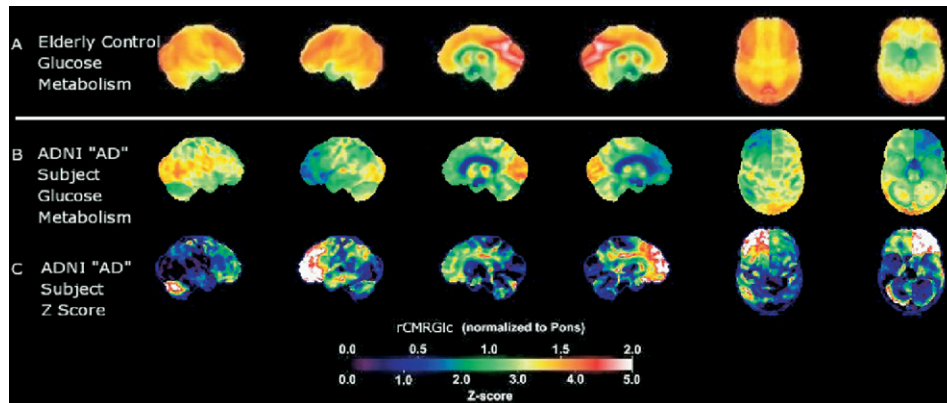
FDG-PET scan in a subject diagnosed with AD who shows an FTD pattern of glucose hypometabolism. Results are displayed as Neurostat SSP images as described in Fig. 1. This scan (rows B and C) is from an AD subject enrolled in the ADNI study who meets NINCDS-ADRDA criteria. The statistical map (row C) is derived from calculating a pixel-by-pixel Z score when compared with 27 normal elderly control subjects (row A). There is hypometabolism predominantly involving the frontal cortex and anterior cingulate gyrus, a pattern typical for FTD. The left hemisphere is more affected than the right, and there is crossed, left cerebellar hypometabolism, frequently observed with severe frontal hypometabolism.
